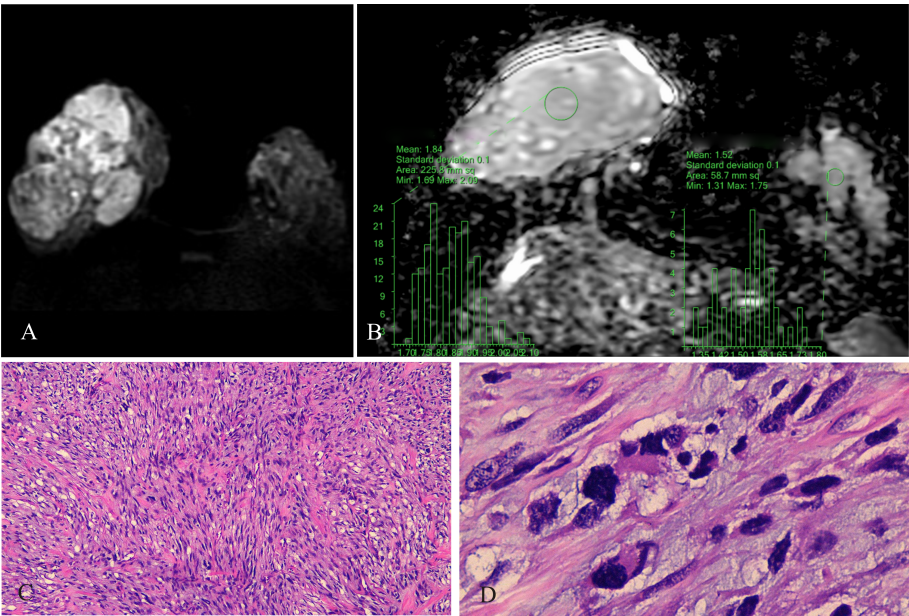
Malignant PT of the right breast, female, age 29 years. (A) DWI (b800 s/mm²): mixed hyperintense signal; (B) ADC map: isointense-hyperintense mixed signal, ADCmean = $1.84 \times 10^{-3} \text{ mm}^2/\text{s}$; ADCmean (left normal breast) = $1.52 \times 10^{-3} \text{ mm}^2/\text{s}$; (C) HE x100: tumor stromal cells were closely packed; (D) HE x400: nuclear fission, interstitial edema was insignificant.
